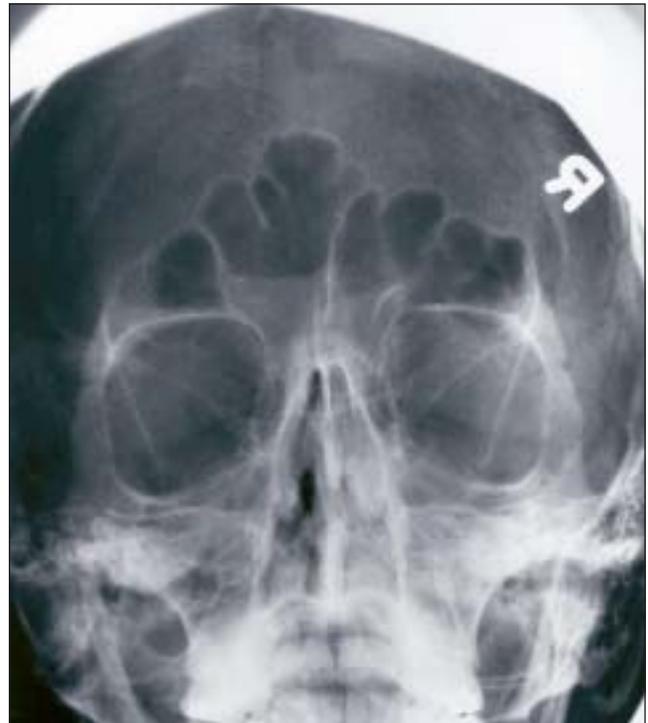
One view of the series of sinus radiographs taken at presentation
